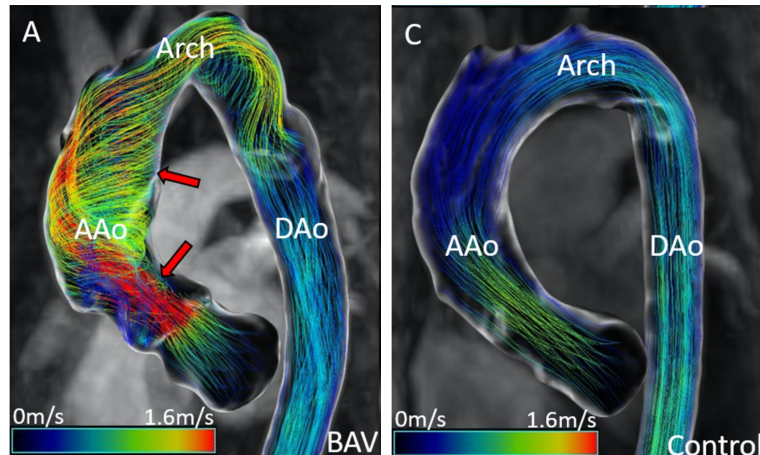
Visualización por 4D-MRI del flujo hemodinámico en la aorta torácica en distintas morfologías valvulares aórticas. Los cambios hemodinámicos producidos por la VAB influyen en el progreso de la DA, promoviendo un flujo turbulento, a diferencia de VAT control en la que el flujo es laminar. AAo: aorta ascendente; Arch: arco; DAo: aorta descendente; BAV: válvula aórtica bicúspide. Adaptación de Gordon et al., 2020⁷⁷.
